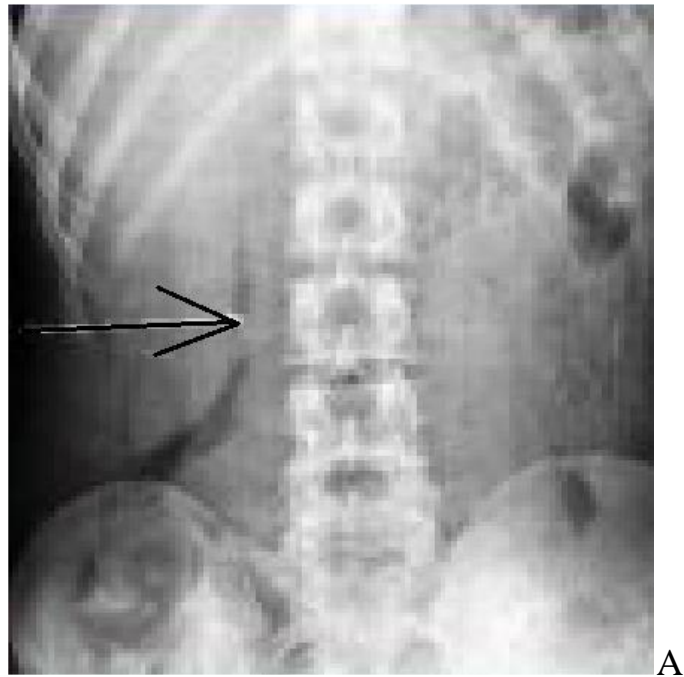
An overview direct X-ray of the abdomen (lying on the back). The presence of free gas in the retroperitoneal space is determined; in the case of contrast, the exit of the contrast material beyond the duodenum into the retroperitoneal space (arrow).
